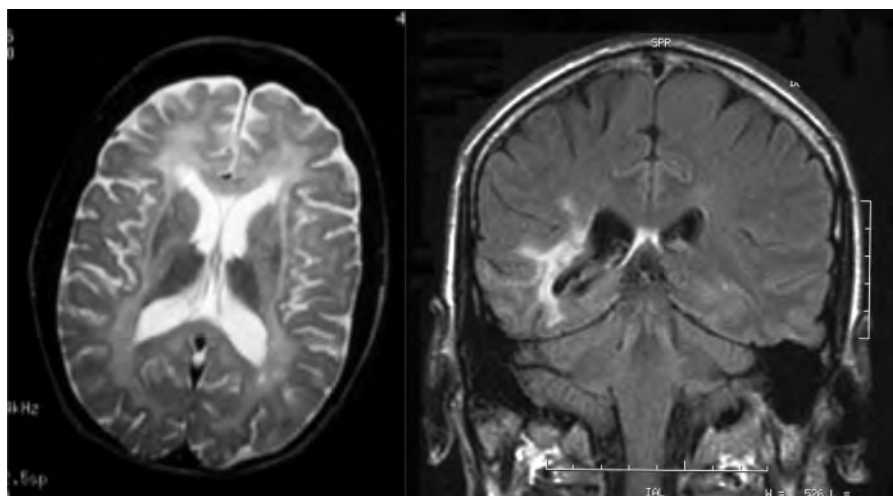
Metachromatic leucodystrophy. (a) MRI T2W axial. (b) MRI T2W coronal.
